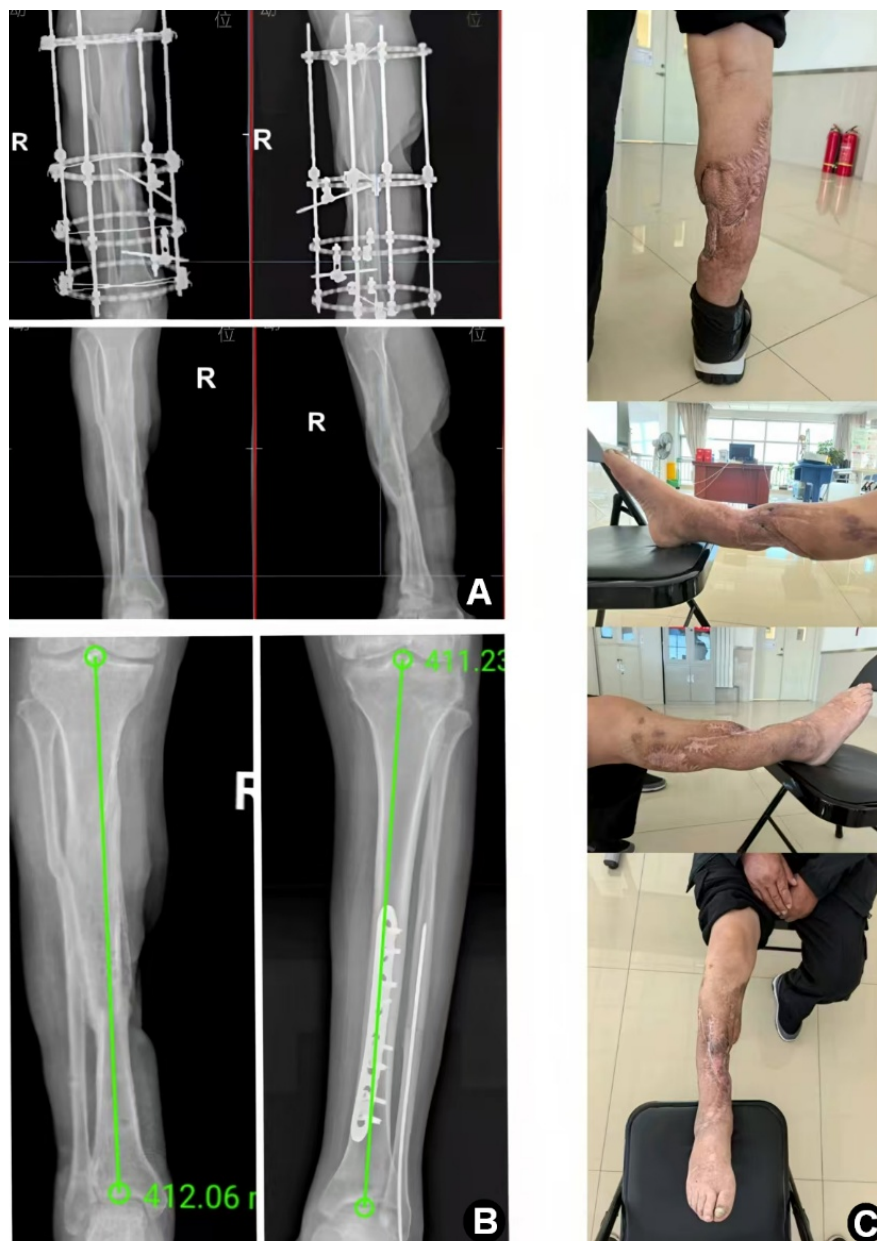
Final follow-up X-ray and local calf photographs.
